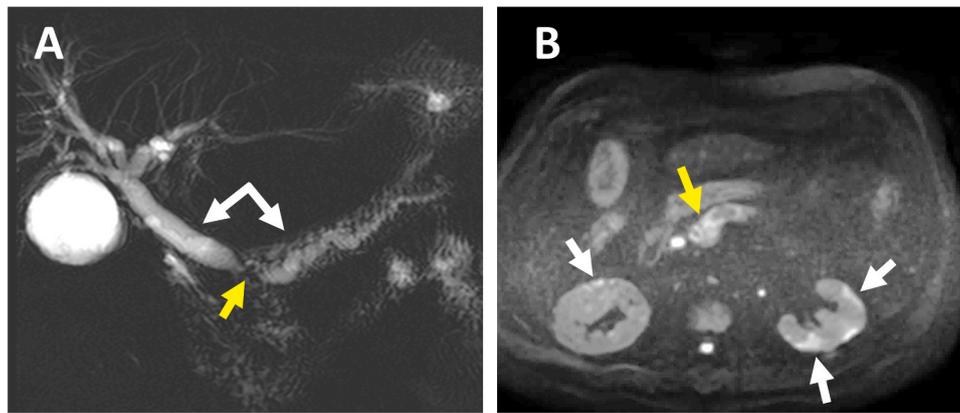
Diagnostic problem-solving with MRI. This patient presented with dilated main pancreatic duct and biliary tree (A, white arrows), highly suspicious for a pancreatic head tumor (yellow arrow). However, DWI revealed not only a restricting pancreatic head (B, yellow arrow), but also areas of restriction in both kidneys (B, white arrows). These findings prompted the diagnosis of auto-immune pancreatitis, which was confirmed after a 2-week steroid trial.
